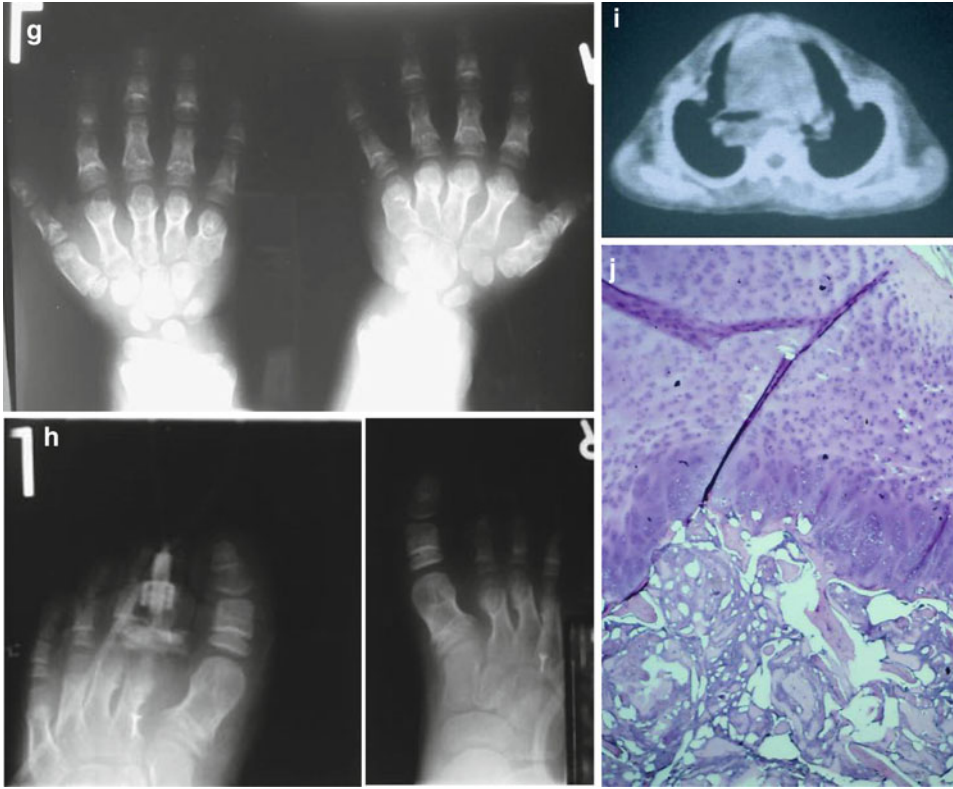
(a–j) A 7-year-old boy with asphyxiating thoracic dystrophy showing a narrow thorax and short limbs. He had dwarfism, postaxial polydactyly, and respiratory distress since birth. Radiographs showed handlebar clavicles, short horizontal ribs, oblique superior acetabular margins, shortened tubular bones, shortened phalanges especially the middle and distal phalanges, and *cone-shaped*
